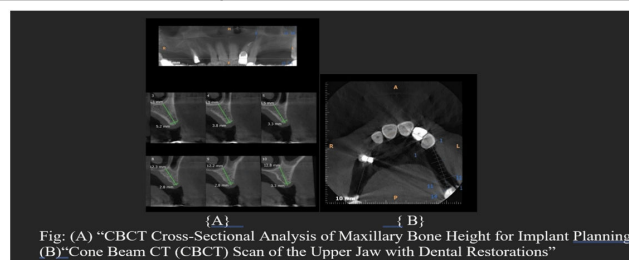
Applications of CBCT in Implant Planning and Post Restorative Evaluation: Axial and Cross-Sectional Views
